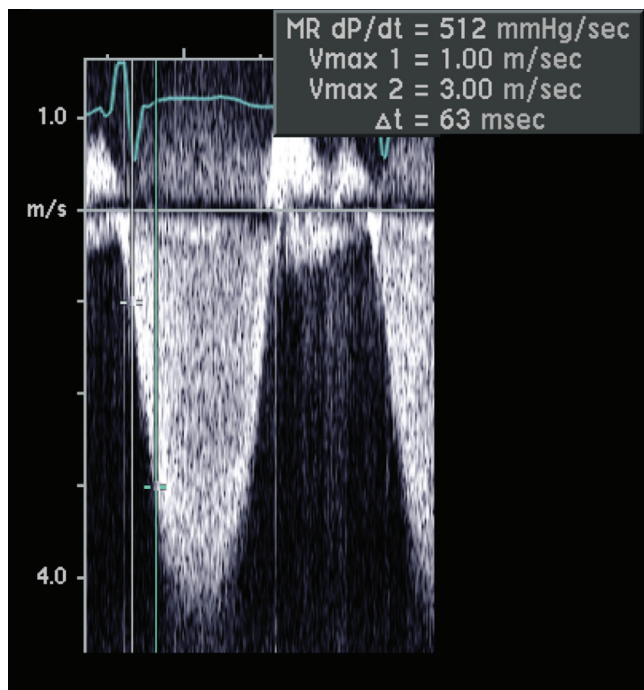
■ Continuous wave Doppler tracings of the mitral regurgitant jet showing a decreased rate of rise to the peak LV cavity pressure during early systole in a patient with severely reduced LV systolic function and ejection fraction of 25% (dP/dt). With normal systolic function, the change in rate of rise in pressure over time should be greater than 1000 mm Hg/sec. Δt , Change in time; V_{max} 1, first velocity measured; V_{max} 2, second velocity measured.
